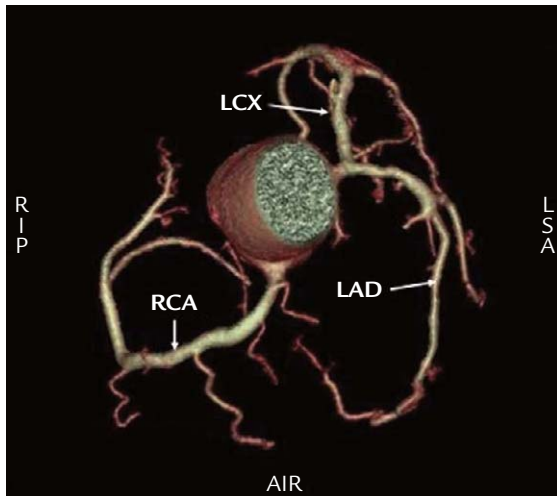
Type I coronary artery anatomic variant as shown on 64-multidetector-row computed tomography. The right coronary artery (RCA) originates from sinus 2. The left anterior descending artery (LAD) and left circumflex artery (LCX) originate from sinus 1.
